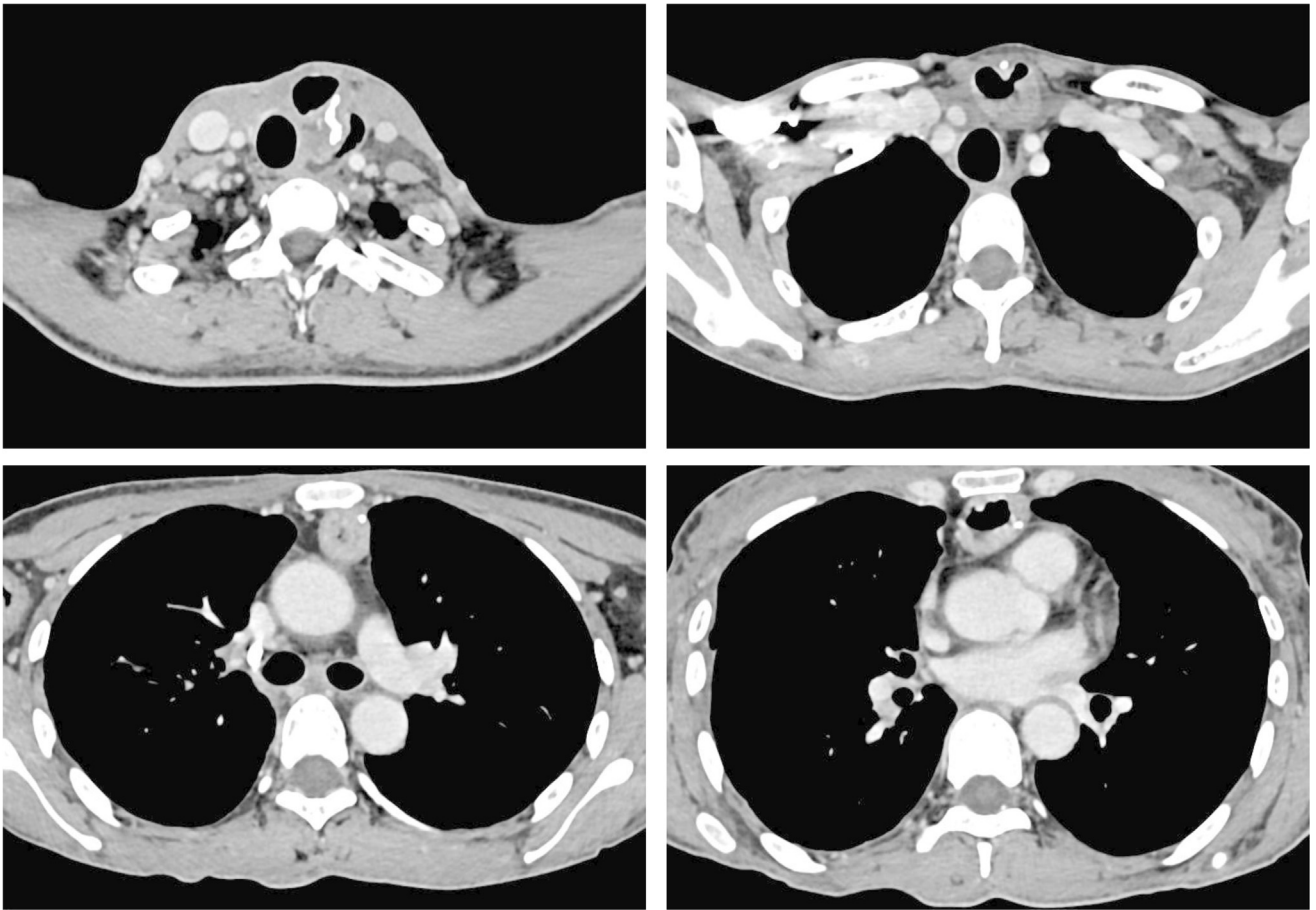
Follow-up computed tomography scan of the neck and chest at 1 month after the surgery.
